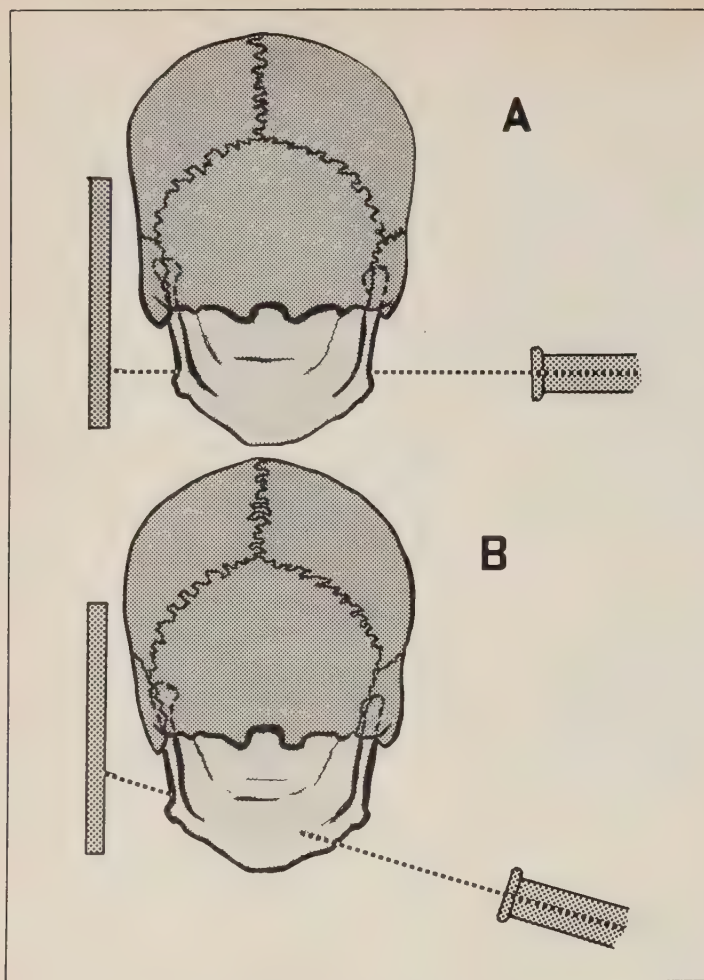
A, the side of the mandible closer to the x-ray tube is superimposed on the side under investigation. B, by directing the beam obliquely the superimposition is removed.
